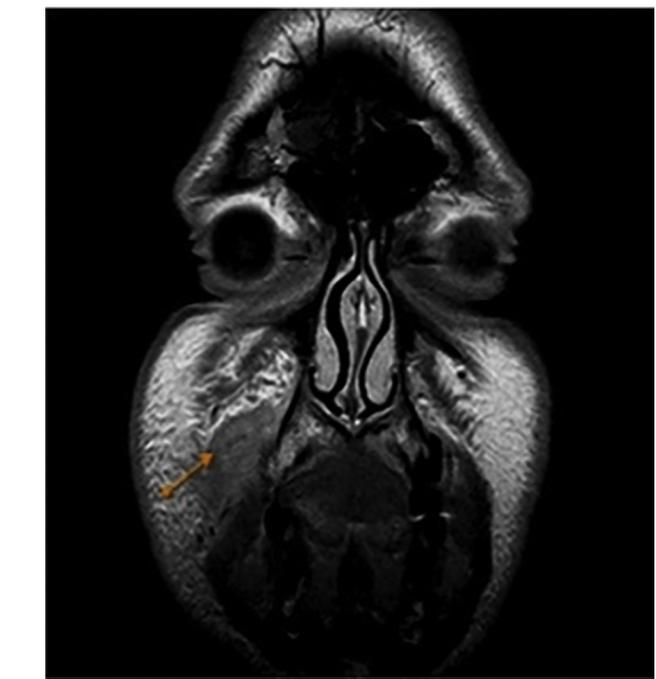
Coronal T1-weighted MR image displays an inhomogeneous, well defined nodular lesion in the posterior part of the right buccal space, in front of right masseter muscle (arrow). The lesion is isointense to the muscle that is not invaded.
